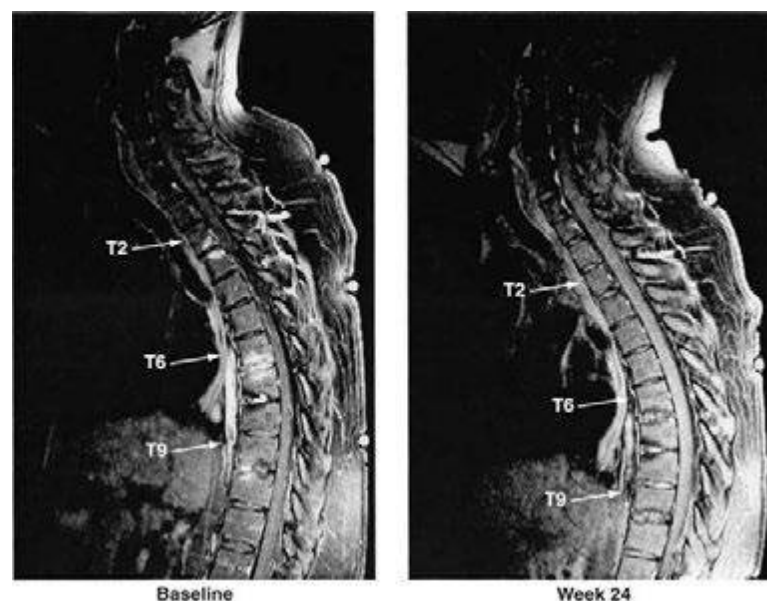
Spinal inflammation (spondylodiskitis) in a patient with ankylosing spondylitis and its dramatic response to treatment with infliximab. Gadolinium-enhanced T1-weighted magnetic resonance images, with fat saturation, at baseline and after 24 weeks of infliximab therapy. (From J Braun et al: *Arthritis Rheum* 54:1646, 2006.)
